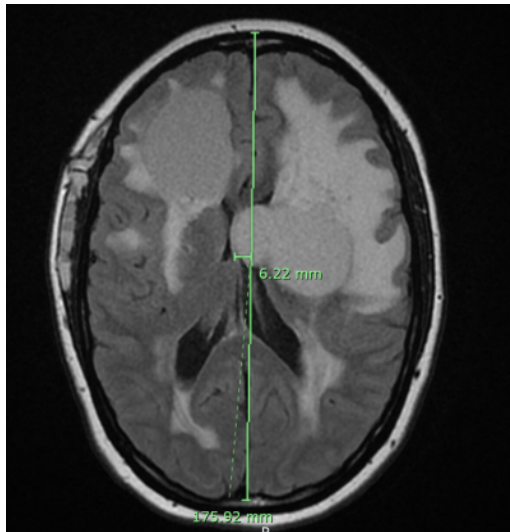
MRI Brain with cystic lesions and midline shift
